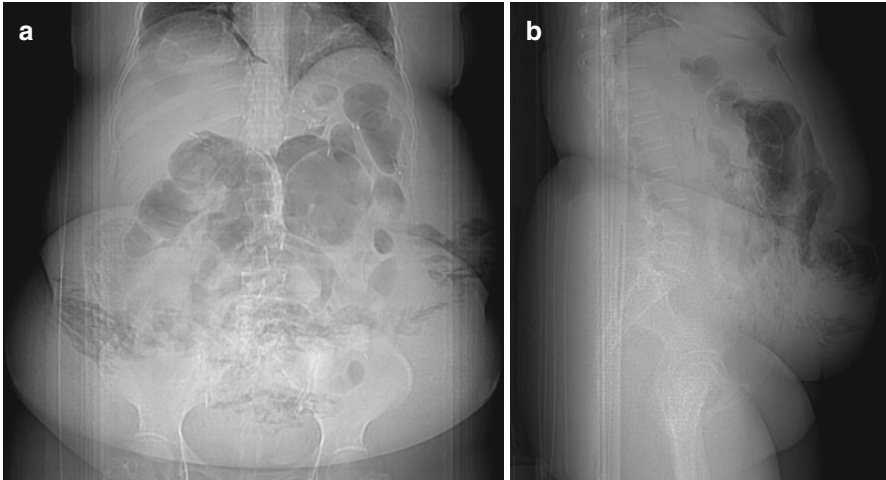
(a, b) A 44-year-old woman post hysterectomy and salpingo-oophorectomy. Postop day 4, presented with abdominal pain. Anterior (a) and lateral (b) scout views from CT scan show extensive subcutaneous gas within the anterior abdominal wall, consistent with necrotizing fasciitis
